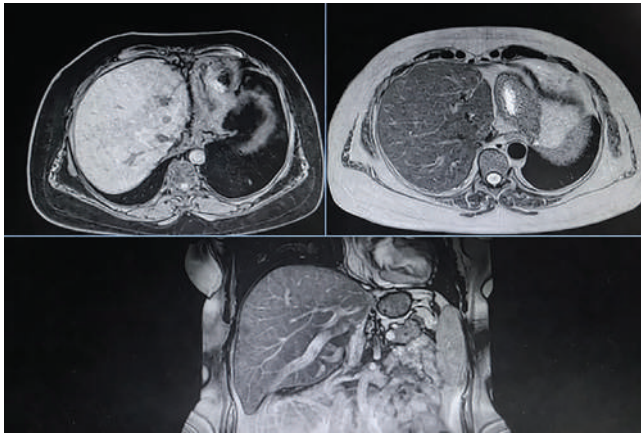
Last follow-up MRI.
